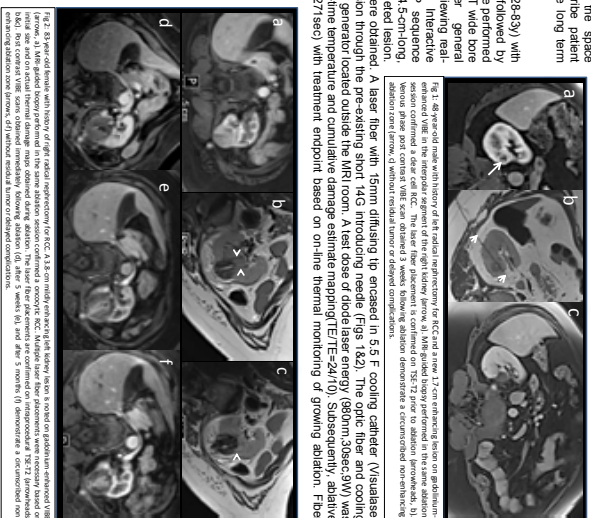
MRI-guided laser ablation procedure. (a) Axial MRI showing a 2.7 cm enhancing lesion on gadolinium-enhanced MRI. (b) Coronal MRI showing the lesion. (c) Axial MRI showing the lesion. (d) Axial MRI showing the lesion. (e) Axial MRI showing the lesion. (f) Axial MRI showing the lesion. (g) Axial MRI showing the lesion. (h) Axial MRI showing the lesion. (i) Axial MRI showing the lesion. (j) Axial MRI showing the lesion. (k) Axial MRI showing the lesion. (l) Axial MRI showing the lesion. (m) Axial MRI showing the lesion. (n) Axial MRI showing the lesion. (o) Axial MRI showing the lesion. (p) Axial MRI showing the lesion. (q) Axial MRI showing the lesion. (r) Axial MRI showing the lesion. (s) Axial MRI showing the lesion. (t) Axial MRI showing the lesion. (u) Axial MRI showing the lesion. (v) Axial MRI showing the lesion. (w) Axial MRI showing the lesion. (x) Axial MRI showing the lesion. (y) Axial MRI showing the lesion. (z) Axial MRI showing the lesion.
